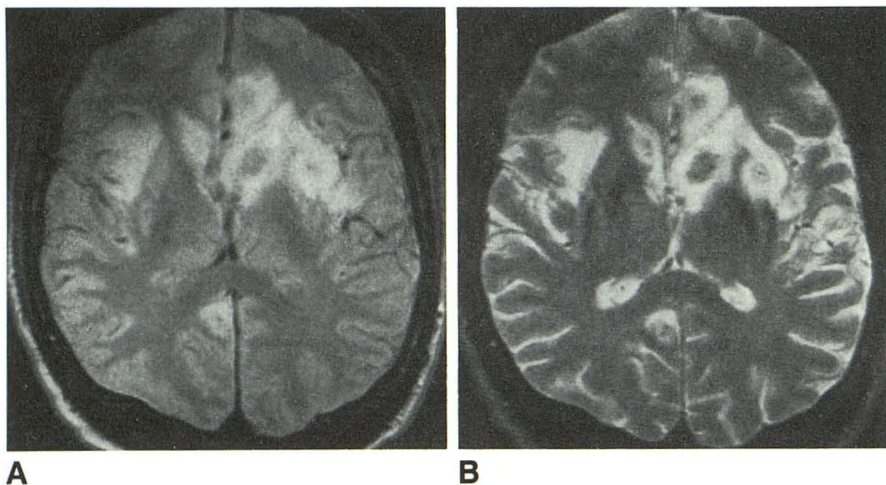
A and B, Case 10. 44-year-old man with AIDS presenting with multiple lesions. Proton density and T2-weighted images (3000/30, 80) show small, slightly hyperintense lesions relative to gray matter with mild edema and mass effect.
